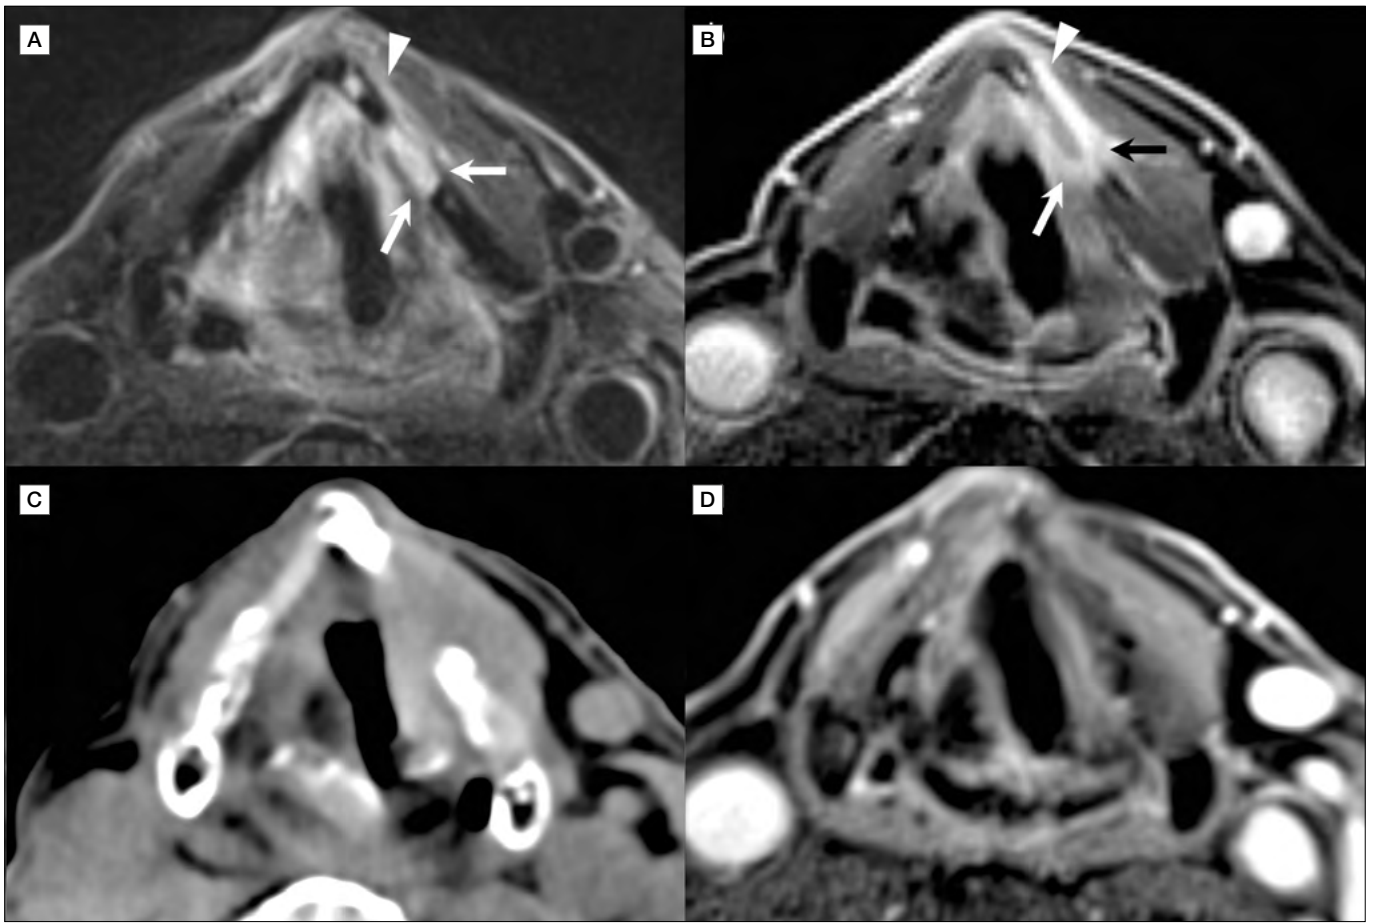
Focal post-CO₂ TOLMS LC in patient No. 4. Axial images at the glottic level: fat-saturated T2-weighted (A), contrast-enhanced fat-saturated T1 (VIBE) (B) and soft-tissues window CT reconstruction (C). Focal signal changes involving the full thickness of the left anterior thyroid lamina (arrows) with very hyperintense T2-weighted signal and intense peripheral contrast enhancement. Note the extension along the external perichondrial surface of the thyroid lamina anteriorly (arrowhead). On CT, focal full thickness erosion of the corresponding segment of the thyroid lamina is depicted (double-headed dashed arrow on C). Axial contrast-enhanced fat-saturated T1 (VIBE) (D) at 11 months follow-up shows complete resolution of the LC process, with no abnormal contrast enhancement areas.
